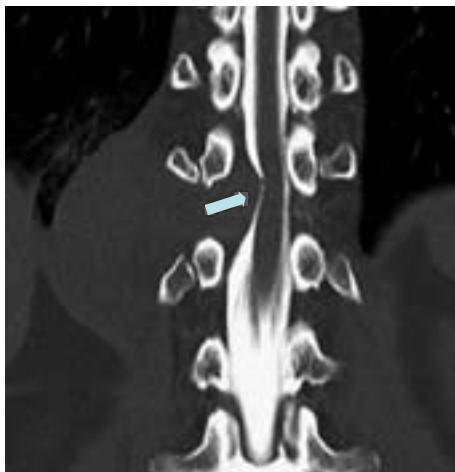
CT myelography reveals that the thoracic spinal cord is markedly compressed by the tumor (arrow).
